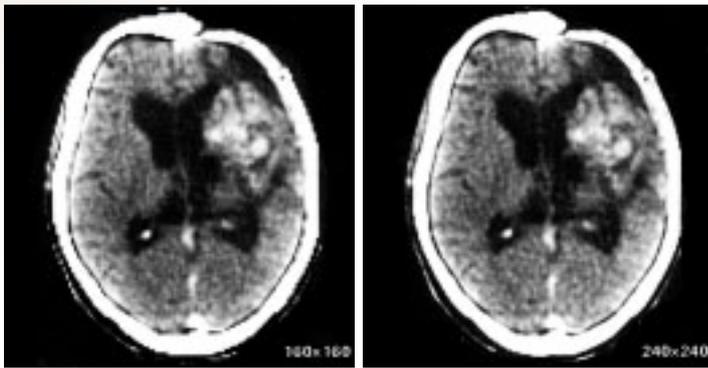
First brain CT images of 160 x 160 matrix (left) and 240 x 240 (right) which took 45 - 130 seconds to reconstruct. They were both of 5 mm slice width.
